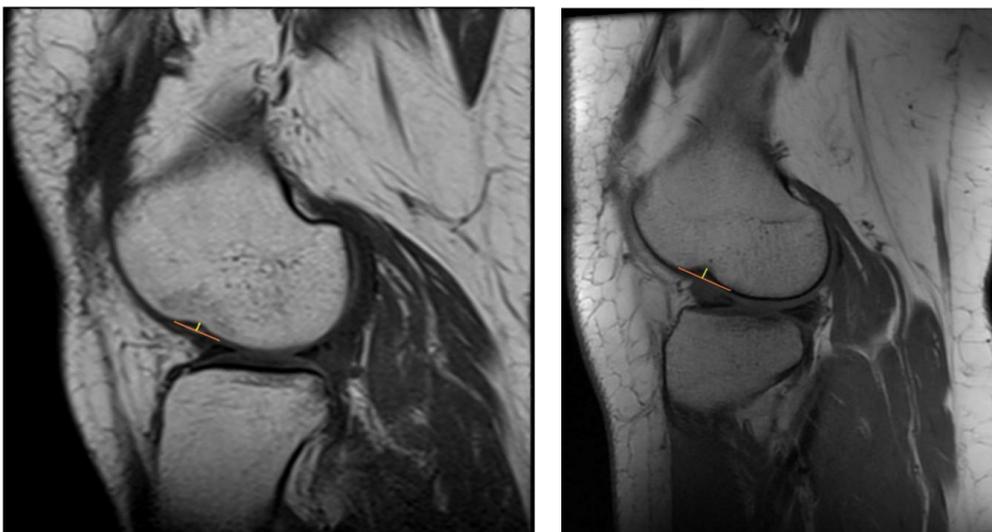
Measurement of the lateral femoral notch sign on sagittal T1-weighted magnetic resonance imaging
